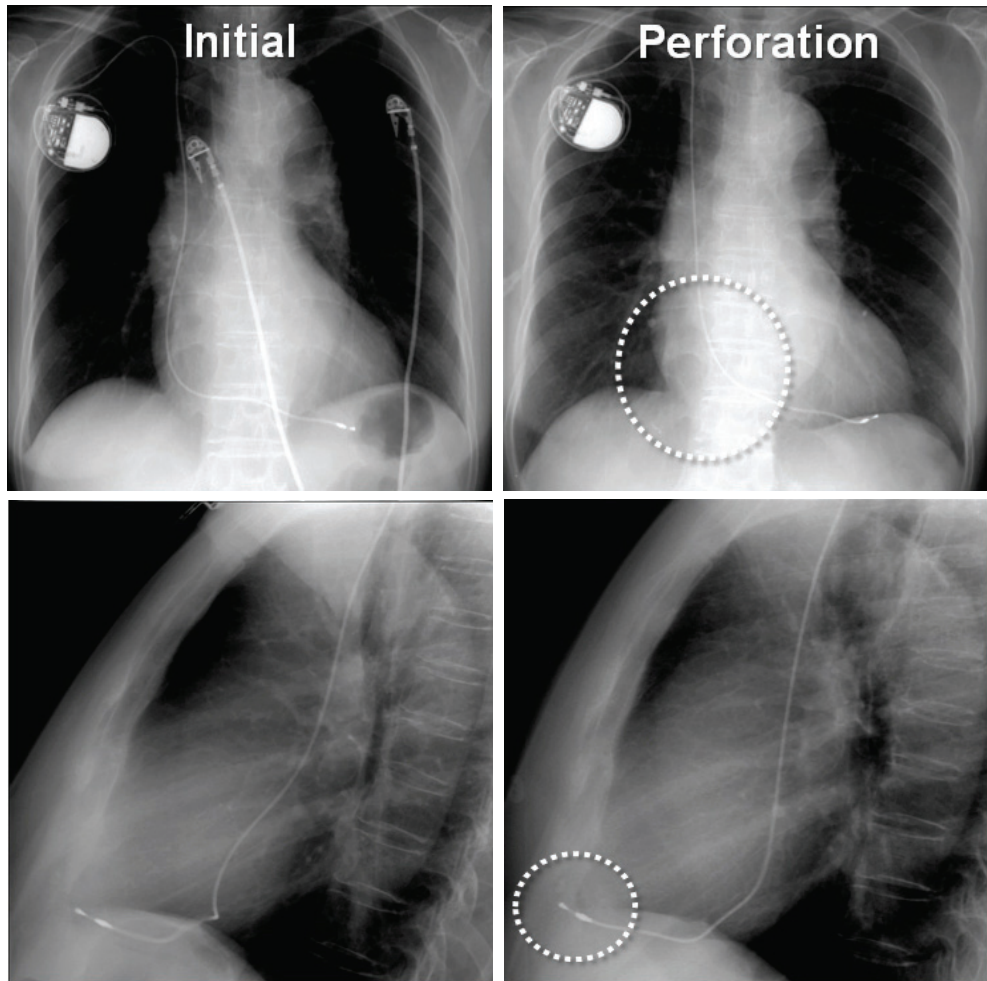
Initial and perforation chest X-ray. In comparison with the initial images, curvature of the lead in the atrial portion (dotted circle in the posteroanterior view) and the lead tip position (dotted circle in the lateral view) were changed.
